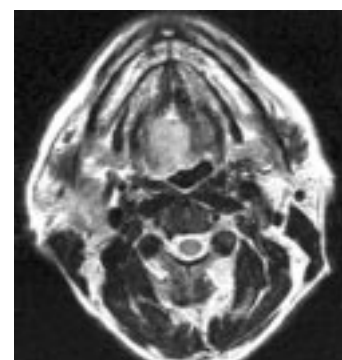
Axial SE T2-weighted MR Image
